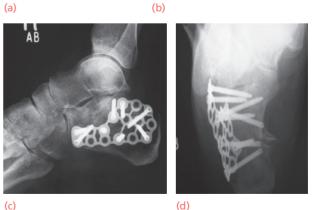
Intra-articular calcaneal fracture – treatment (a) X-ray gives limited information, but the CT (b) shows the severe depression of the posterior calcaneal facet. This was treated operatively with a calcaneal locking plate, to reconstitute the posterior facet (arrow) and restore the height of the calcaneum (c,d). up non-weight-bearing on crutches. Partial weightbearing is permitted only when the fracture has healed (seldom before 8 weeks) and full weight-bearing about 4 weeks after that. Restoration of function may take
